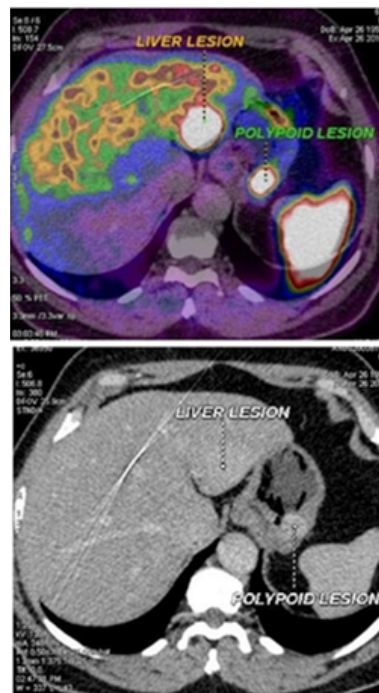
Detection of metastasis by DOTANOC and CT scan.
